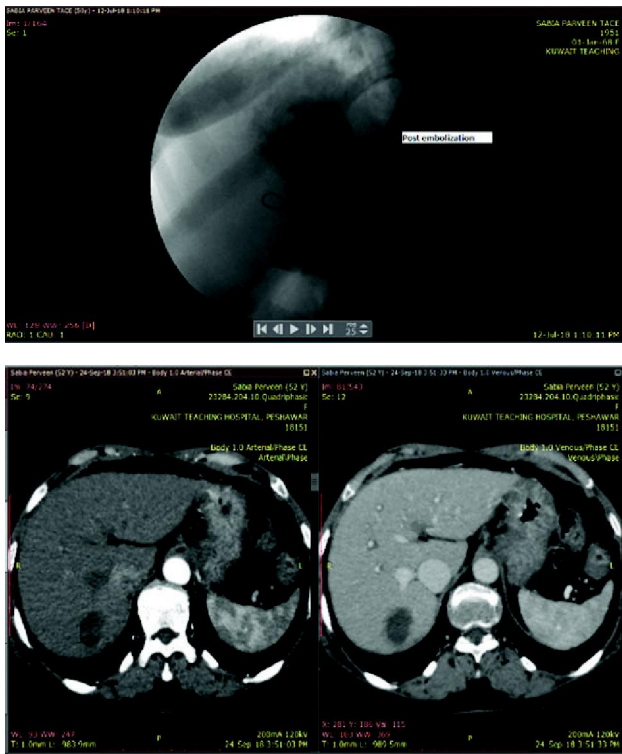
Complete response of HCC in right lobe of liver on follow up Quadraphasic CT after TACE
